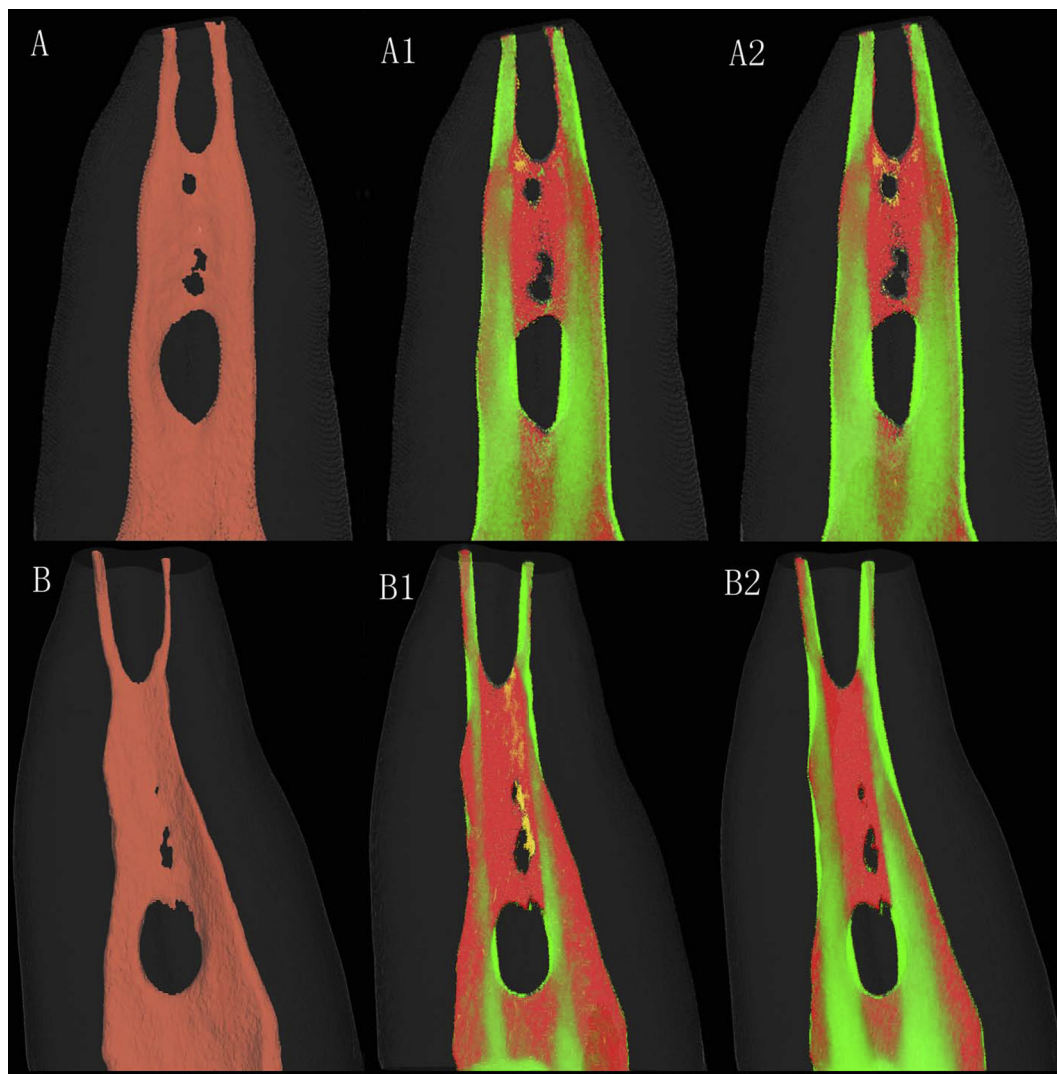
Three-dimensional reconstruction and superimposition of MCT scans of the root canal system of the maxillary premolar under investigation. (A,B) The initial canal configuration showing the complex isthmus area. The top root canals were prepared using (A1) ProTaper Universal as glidepath enlargement and then using (A2) SAF, and the bottom root canals were prepared using (B1) ISO files as glidepath enlargement and then using (B2) SAF. (A1,2, B1,2) Superimposed MCT reconstructions after instrumentation. Prepared areas, untouched areas, and hard-tissue debris are indicated in green, red, and yellow, respectively. ISO = ISO NiTi files; MCT = microcomputed tomography; SAF = self-adjusting files.
